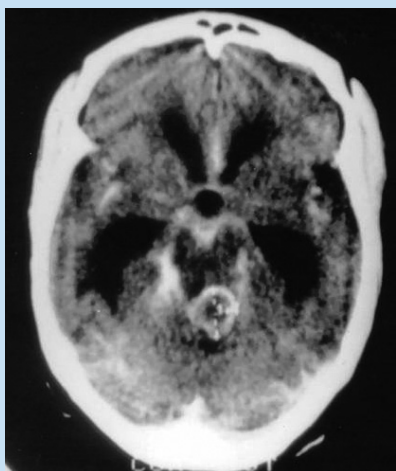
CT scan of the brain (post intravenous contrast) in a patient with tuberculous meningitis demonstrating a left cerebellar enhancing lesion abutting the adjacent brainstem (tuberculoma); increased basal meningeal enhancement and obstructive hydrocephalus with associated subependymal oedema.
